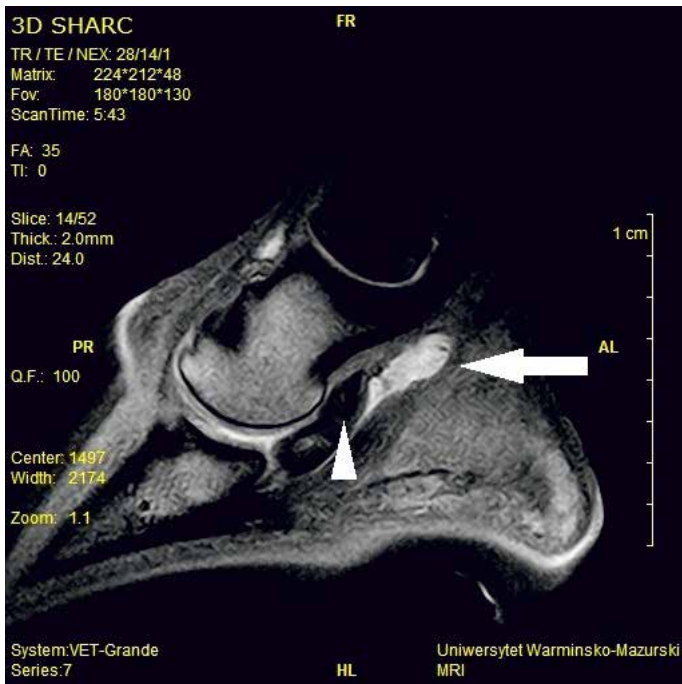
Patient 1, cross-section of the limb shown in Figure 2, T1-weighted sequence in dorsal plane. Visible hyperintensive core lesion on the medial side of the deep digital flexor tendon
